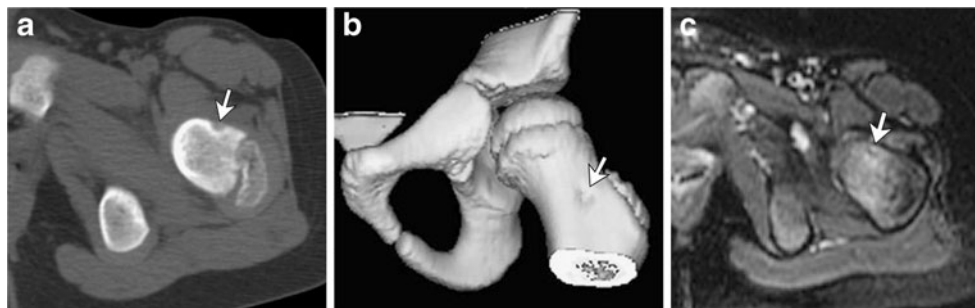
Subperiosteal osteoid osteoma in a 6-year-old boy with left hip pain. a Axial CT image through the center of the nidus demonstrates the subperiosteal location of the radiolucent nidus (*arrow*) with a tiny central dot of calcification. b Reformatted 3-D CT image demonstrates the excavation (*arrow*) of the femoral cortex exerted by the nidus. c
